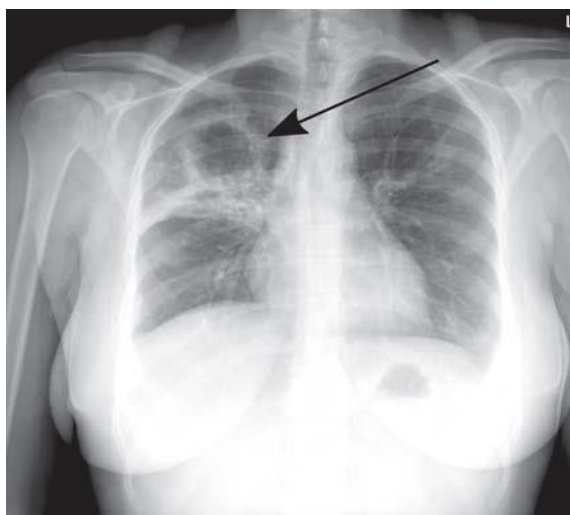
Pulmonary tuberculosis with a big hollow (arrow) in upper field of the right lung (chest radiograph, perpendicular view)
